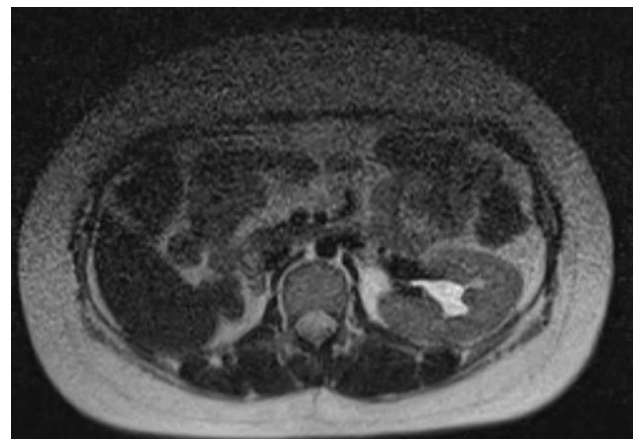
Axial MRI showing absent right kidney and a normally located left kidney with preserved corticomedullary differentiation and mild hydronephrosis.
